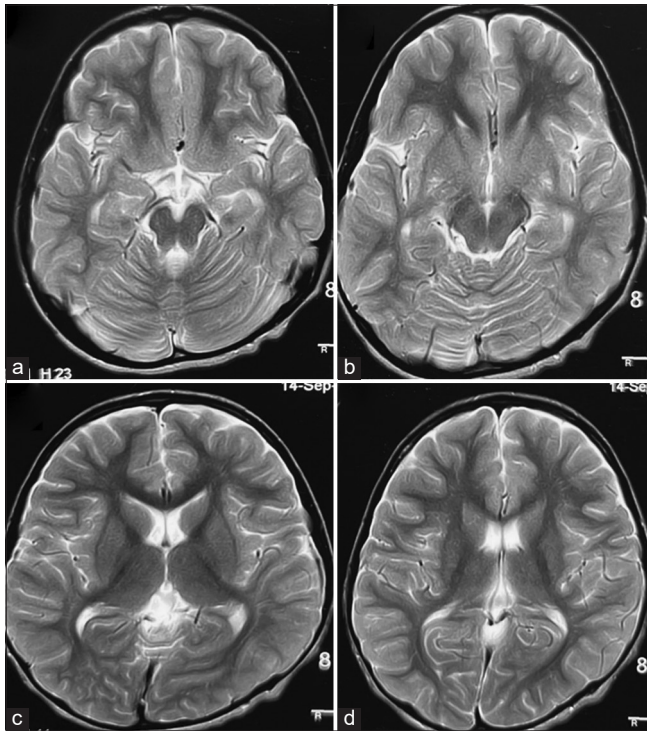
(a-d) Magnetic resonance imaging brain-T2W axial sections at 1 year of age show diffuse cerebral atrophy, widened Sylvian fissure with prominent subdural spaces.
